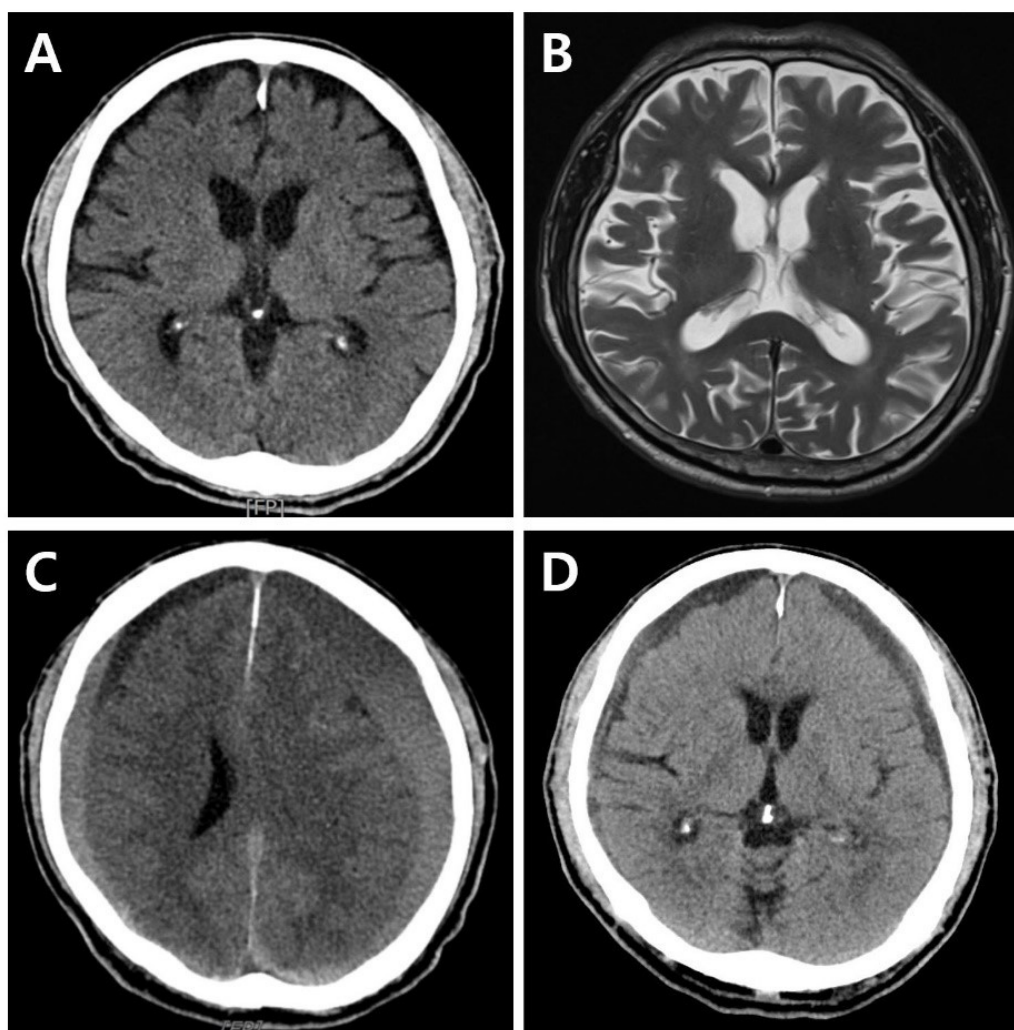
Brain images of the patient. (A) Brain computed tomography scan obtained on the day of injury shows no intracranial pathology. (B) T2-weighted axial image obtained seven days after the mild head injury shows no intracranial bleeding. (C) Brain computed tomography scan obtained five weeks after the head injury demonstrates bilateral chronic subdural hematoma (SDH) with midline shifting. (D) Brain computed tomography scan obtained 2 months after burr-hole trephination reveals residual SDH in both frontoparietal areas but improved midline shifting.
